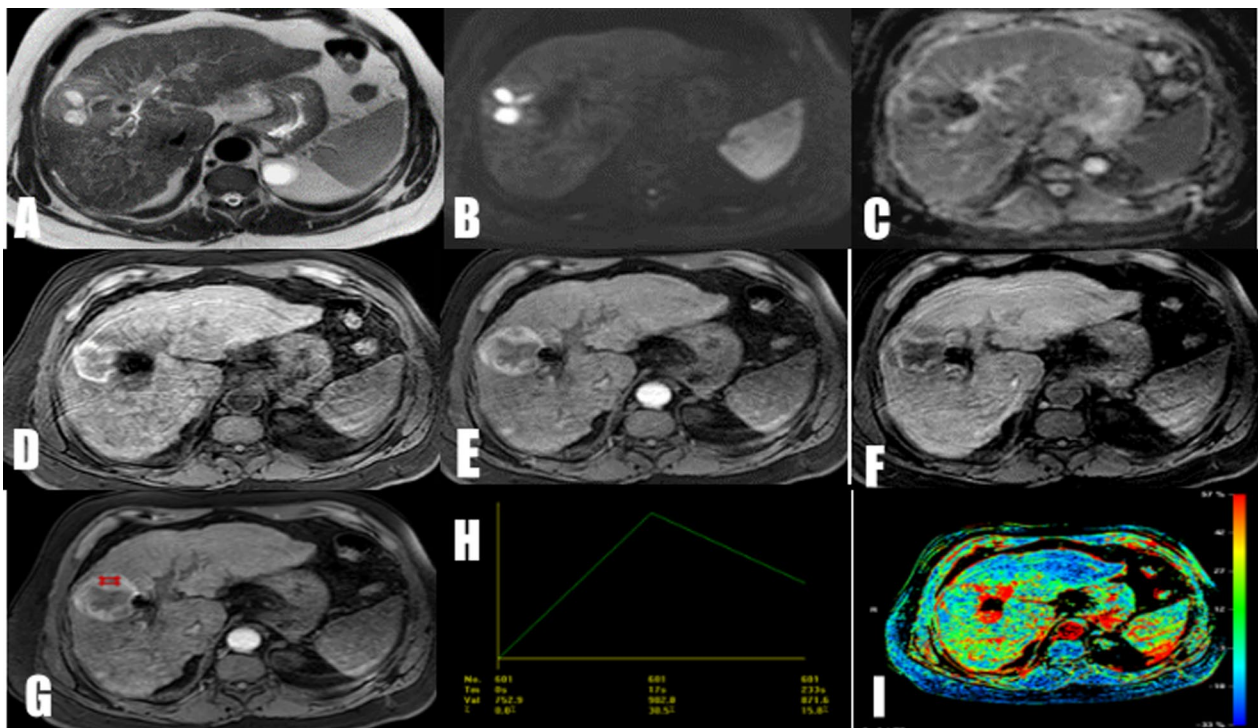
MR imaging of male patient 1 m after microwave ablation. A Axial T2 seq. reveals central coagulative and liquefactive necrosis with hemorrhagic component as well as reveals peripheral hyperintensity at its lateral aspect and small foreign body at its medial aspect displaying signal void (suggesting broken needle). B & C Diffusion MR study and ADC map reveals central area of restricted diffusion within ablated lesion corresponding to liquefactive necrosis with hemorrhagic component. D, E & F Dynamic MR study reveals peripheral enhancement of ablated lesion at arterial phase with delayed washout. G & H Time insanity curve reveals type III curve of ROI placed at periphery of ablated lesion denoting viable tumor tissue. I color map also reveals enhancement at periphery of ablated lesion
